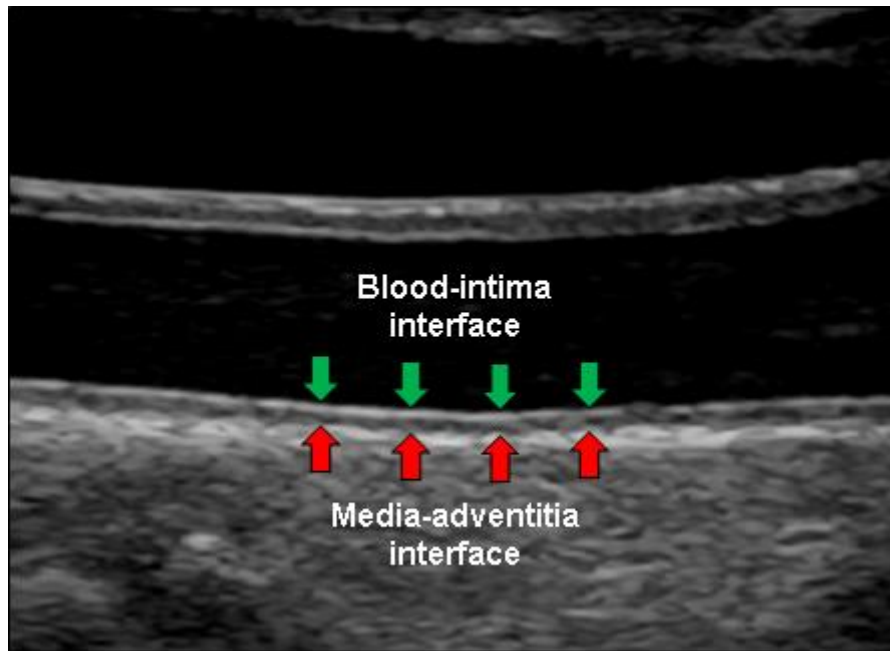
A typical ultrasonographic image of carotid intima-media thickness (cIMT). The most luminal echogenic (i.e. bright) line is generated by the blood-intima interface, whereas the most external echogenic line is generated by the media-adventitia interface. The two lines are separated by an anechoic (i.e. dark) space.
